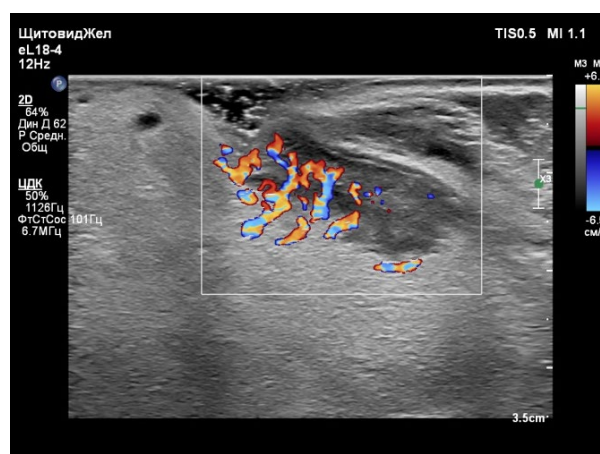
Color Doppler ultrasound image of a tongue tumor: hyperintense intra- and perinodular blood flow.
